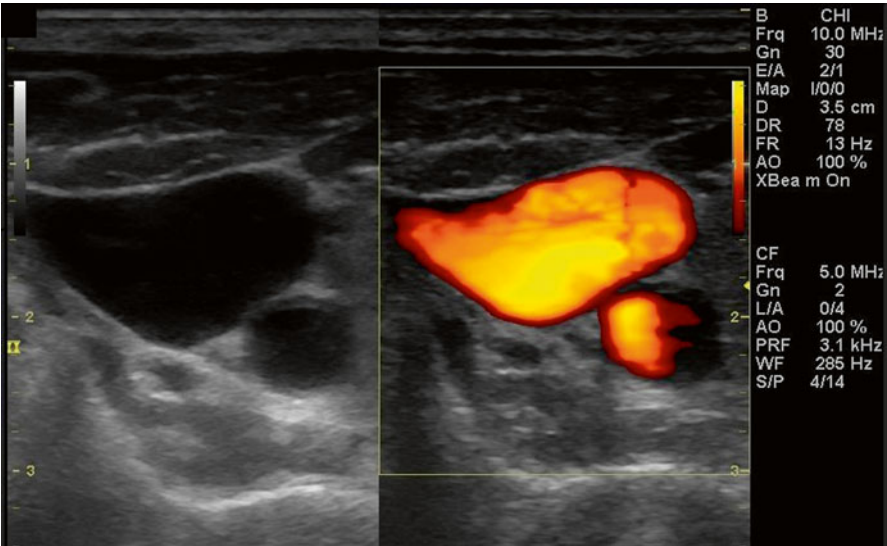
Showing the monitor display during power Doppler mode. Observe that there is no blue color
